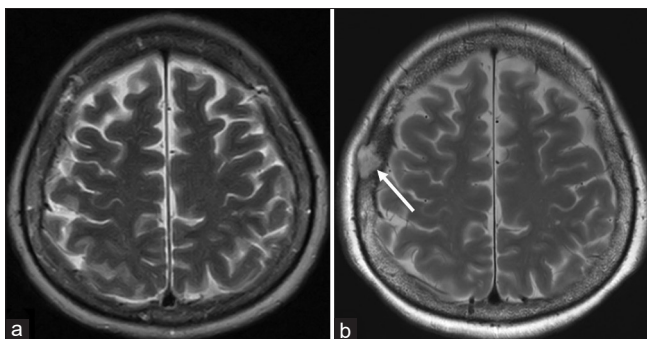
Axial T2-weighted magnetic resonance imaging performed near the same level, at the initial presentation to a local physician (a) and 6 weeks later (b), showing an emergence of a tumor in the right calvarial convexity (b, arrow).
